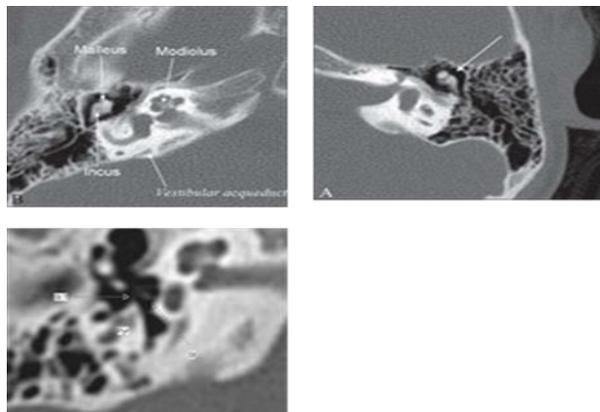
(a) Left axial CT scan temporal showing incus and malleus. (b) right axial CT scan cut temporal showing association with modiolus and vestibular aquaduct (white arrow). (c) bone stapes (white arrows)
